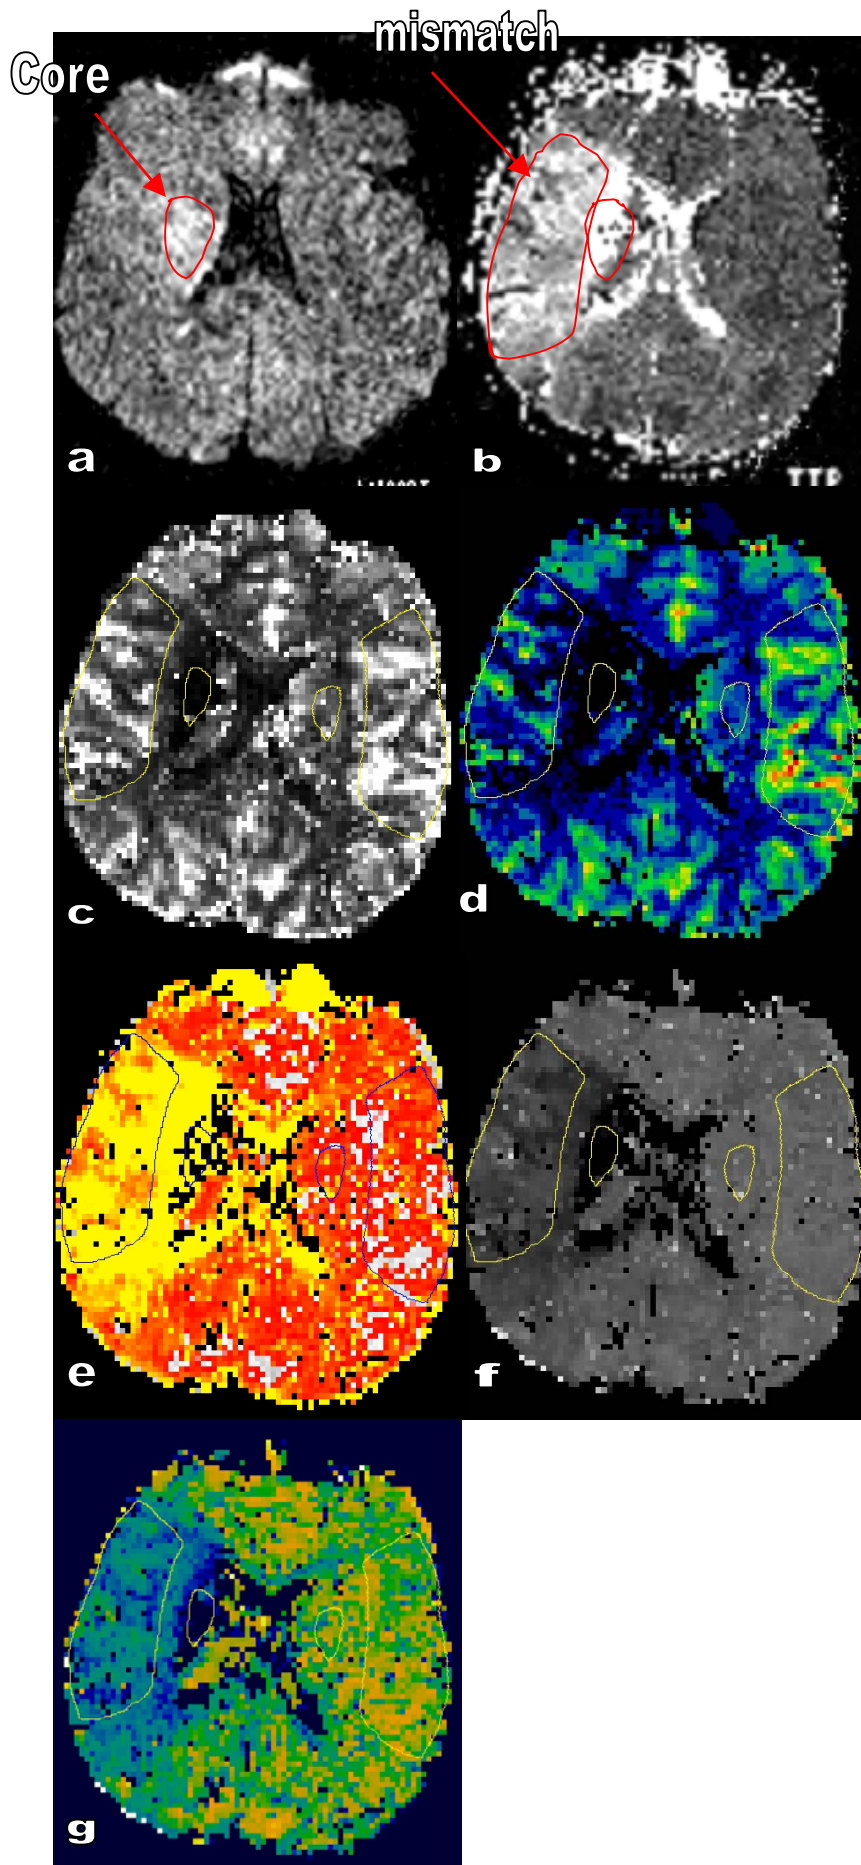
On *a*. DWI the hyperintensity was recognized as ischemic core; and on *b*. TTP, the area normal on DWI but abnormal on MTT map was recognized as mismatch; On *c*. CBV; *d*. CBF; *e*. MTT; *f*. TTP and *g*. T0 maps, the ROIs were manually drawn in the ischemic core and the mismatch region on the perfusion maps, and were rotated to the mirror region on each map.
